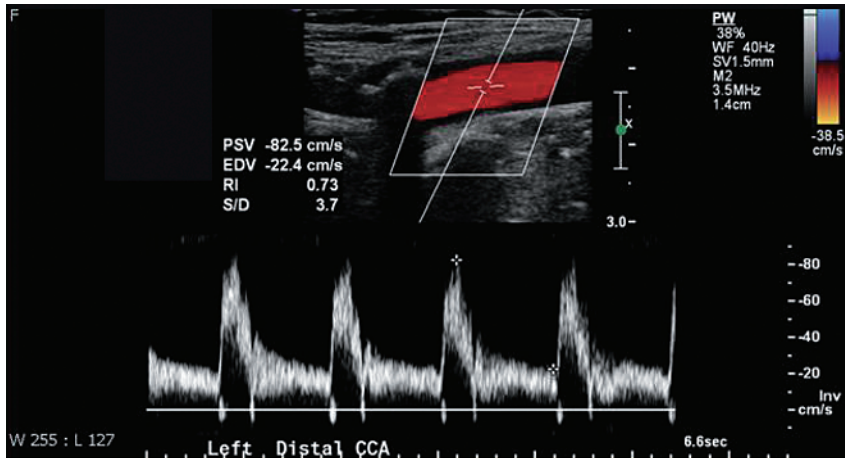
A left CCA Doppler waveform. Normally, 80% of CCA flow is directed to the ICA. Normal CCA end-diastolic flow is therefore generally well above baseline and more closely resembles an ICA rather than ECA waveform.
